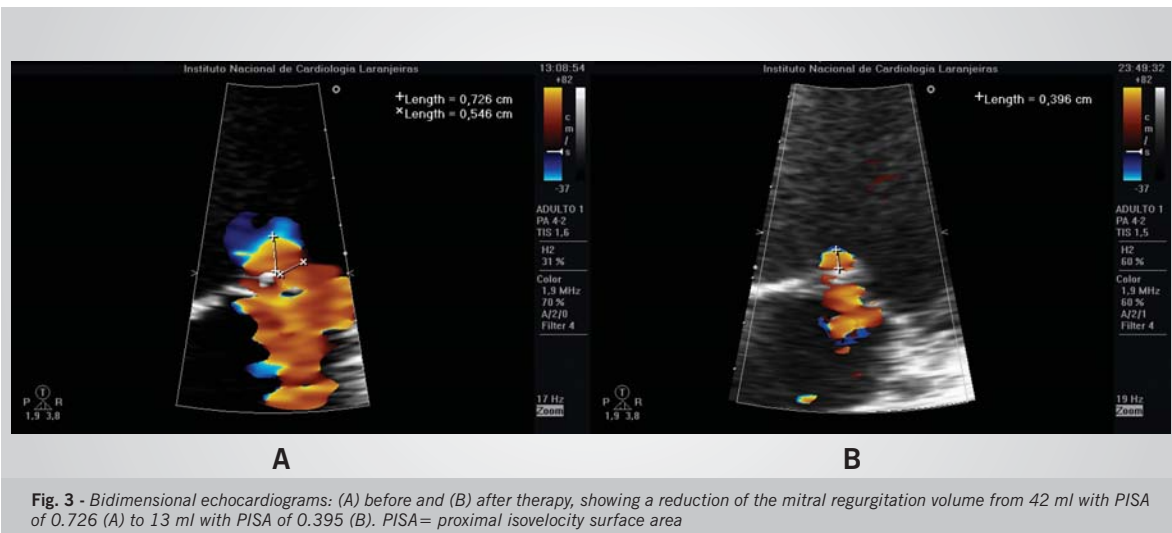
Bidimensional echocardiograms: (A) before and (B) after therapy, showing a reduction of the mitral regurgitation volume from 42 ml with PISA of 0.726 (A) to 13 ml with PISA of 0.395 (B). PISA= proximal isovelocity surface area
